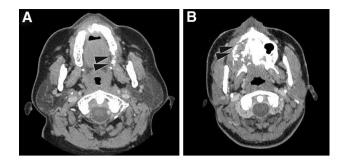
Radiologic features of RMS. CT scans of a ERMS (case 1); b ARMS (case 4), showing destructive invasion of bone by tumor cells as indicated by *arrowheads*
